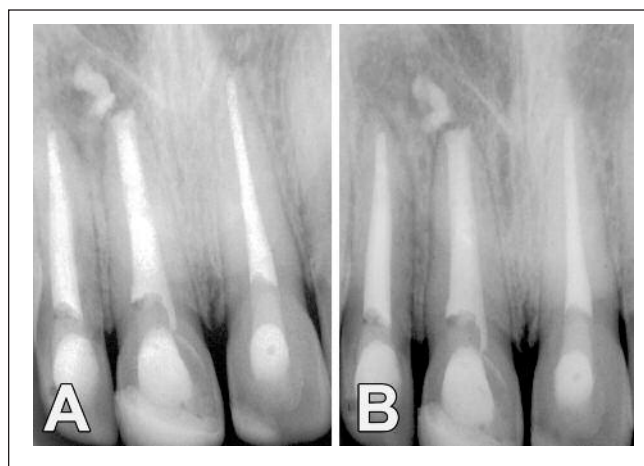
Periapical radiograph of the teeth 1 year (A), and 2 years (B) after treatment. Note the extent of advanced osseous healing and regeneration of periapical tissues.
